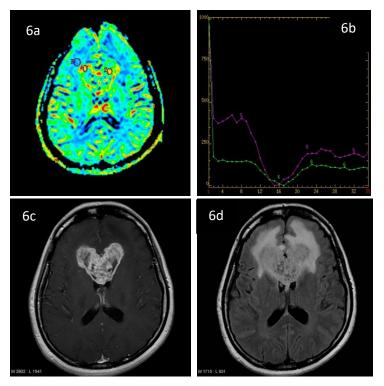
6: 6a: axial CBV ROI 2-4; 6b: CBV graphic ROI 2-4; 6c: axial T1 CEWI; 6d: axial T2 FLAIR. Adapted from: Case of A.Prof Frank Gaillard, Radiopaedia.org, rID: 5290
